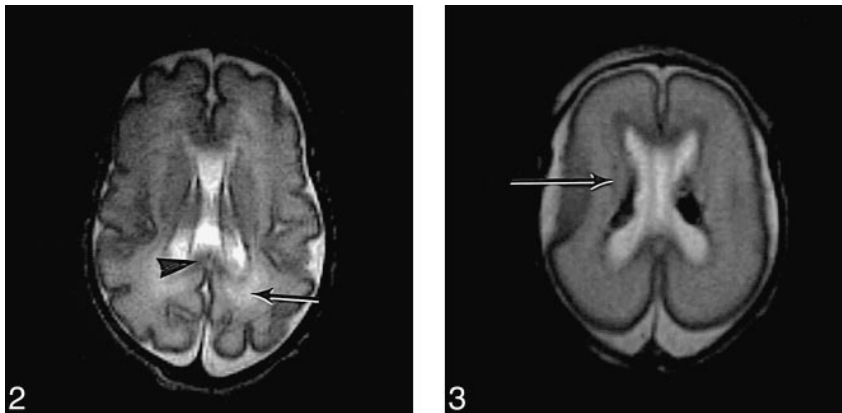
T2-weighted (3500/208) FSE sequence in preterm infant (not in study) of 26 weeks' gestation at age 5 weeks shows normal appearance of the *corpus callosum* (*arrowhead*) in the posterior periventricular white matter (*arrow*).
